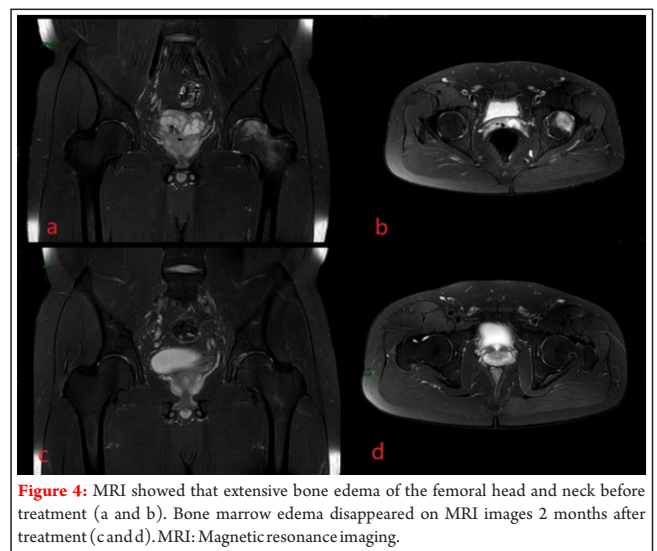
MRI showed that extensive bone edema of the femoral head and neck before treatment (a and b). Bone marrow edema disappeared on MRI images 2 months after treatment (c and d). MRI: Magnetic resonance imaging.
